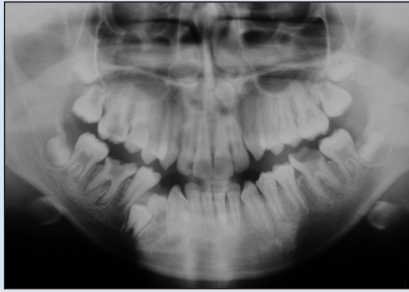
Orthopantomogram, taken when the patient was 11 years, 11 months of age, shows the presence of a premaxillary mesiodens and a mandibular right supplemental premolar.
